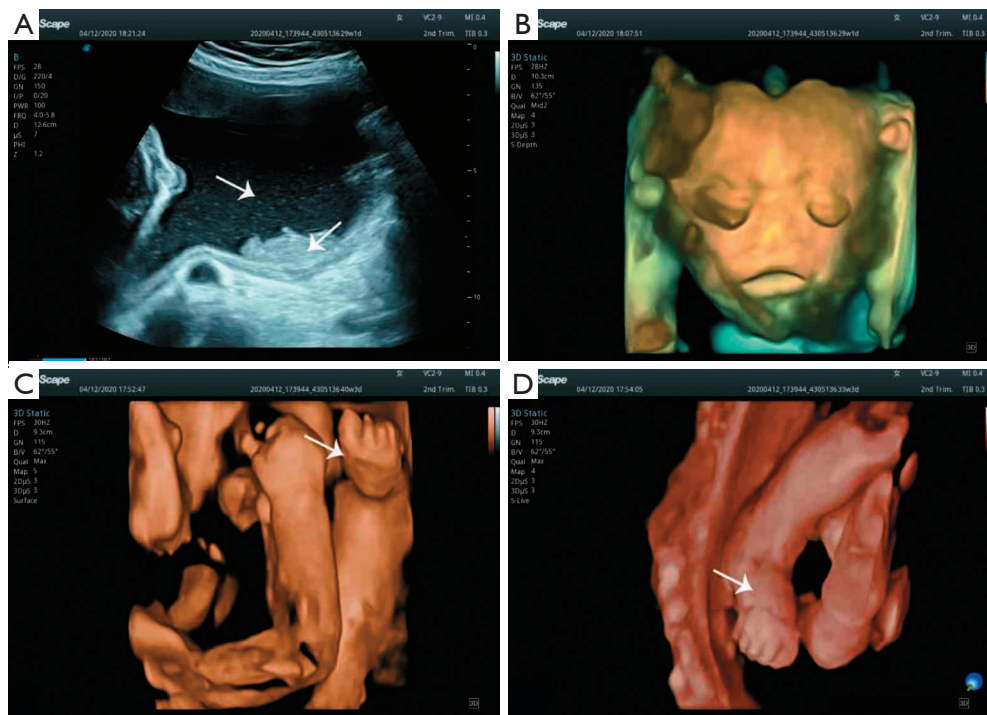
Three-dimensional ultrasound. (A) The dense floating particles in amniotic fluid (arrows); (B) the harlequin phenotype (“clown-like face”); (C) the contracted and edema hands (arrow); (D) the contracted and edema feet (arrow).
